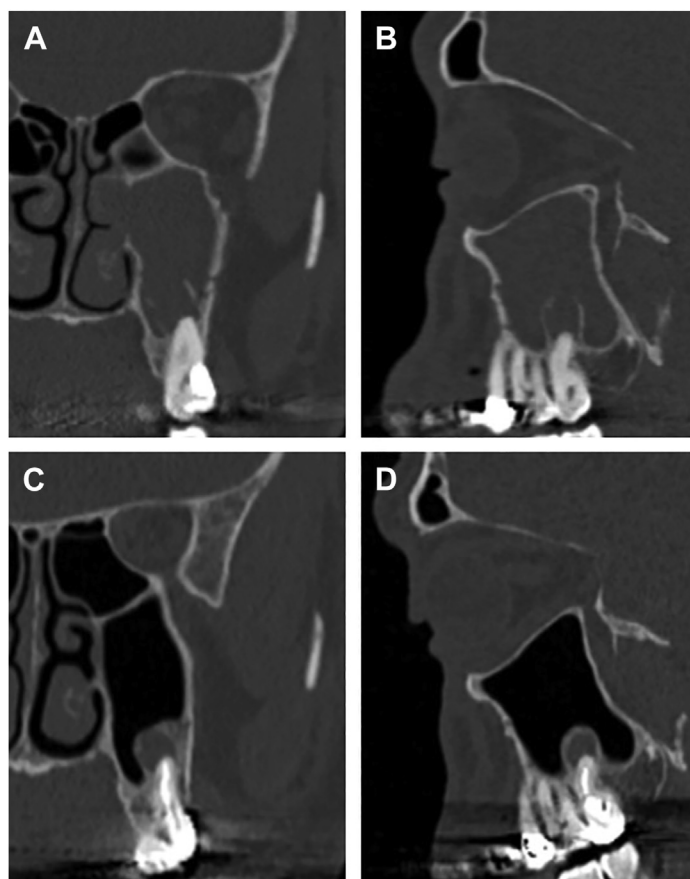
Example of a patient with purulent left-sided maxillary ODS that resolved with RCT alone. (A, B) Coronal and sagittal CT scans showing left maxillary sinus complete opacification and a second maxillary molar with apical periodontitis and a large periapical abscess with bone erosion. (C, D) Six-month post-treatment CT scans showing complete resolution of the maxillary sinus disease, and successful RCT with significant regression in size of the periapical radiolucency.
